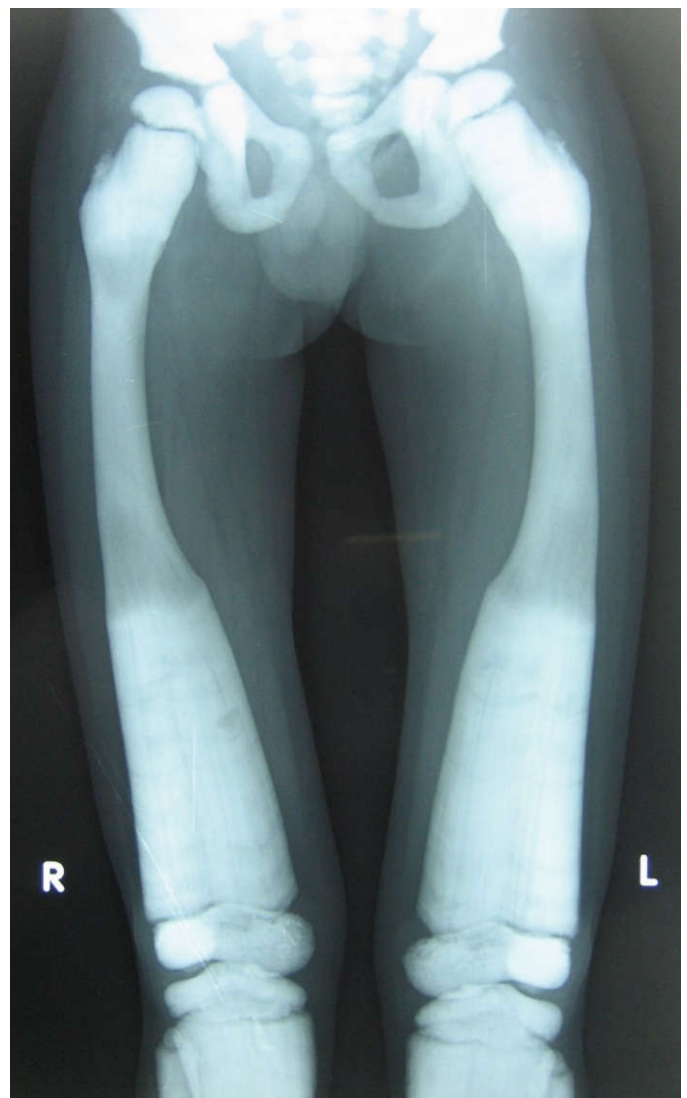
Femur – knee joint radiograph shows generalized increased bone density. Loss of corticomedullary differentiation with loss of medullary spaces. Erlen-meyer flask appearance
